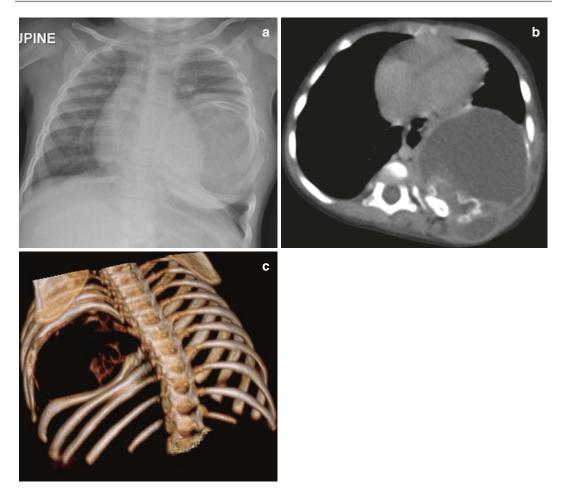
Mesenchymal hamartoma of the chest wall. (a) Plain radiograph at presentation demonstrates a large soft tissue density mass involving a left posterior rib with splaying of the adjacent ribs suggesting a slow growing pathology. (b) Contrast enhanced axial CT shows a mass
